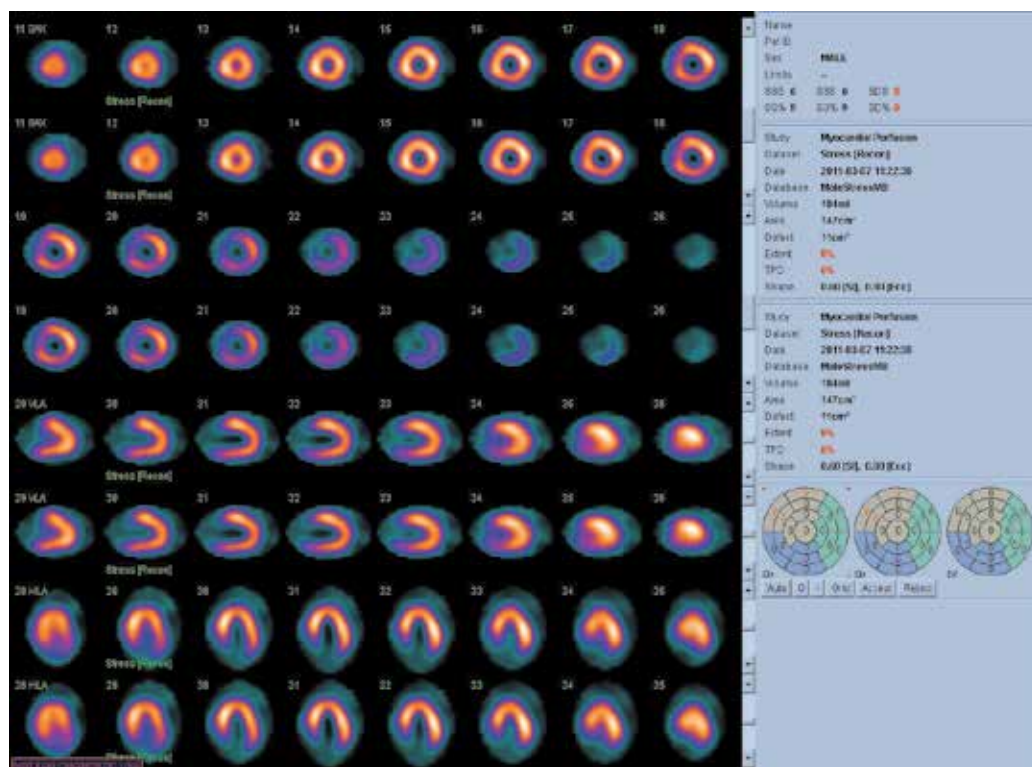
Myocardial scintigraphy - dilative cardiomyopathy and ischemic areas on stress.
